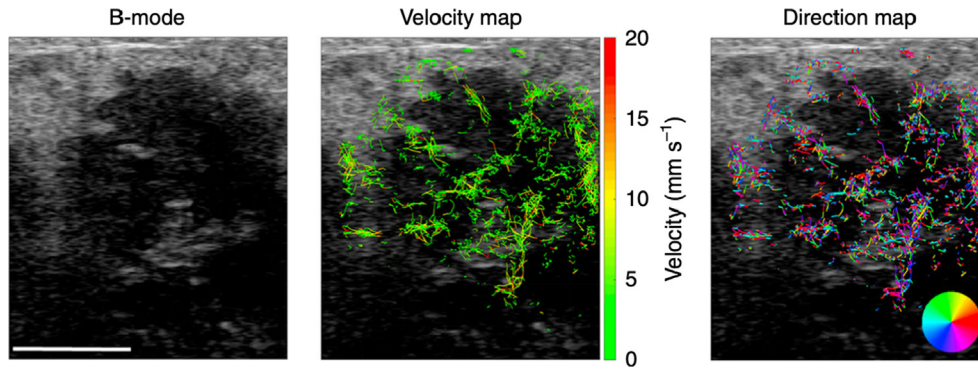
Super-resolution ultrasound imaging of a patient with HER2 positive breast cancer. The vascular map reveals heterogeneously distributed microvessels throughout the tumor. (Images adapted from Opacic *et al.*, 2018 [21]).
